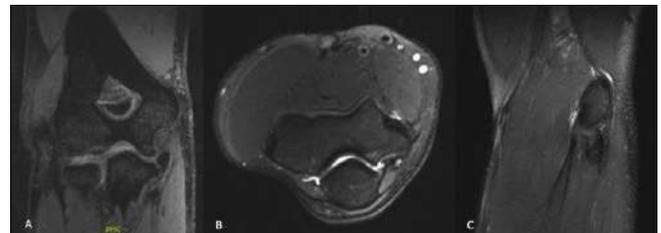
T2-weighted elbow MRI demonstrating the fibrous nonunion of the sublime tubercle and hyperintense signal along deep and proximal portion of the common flexor origin
